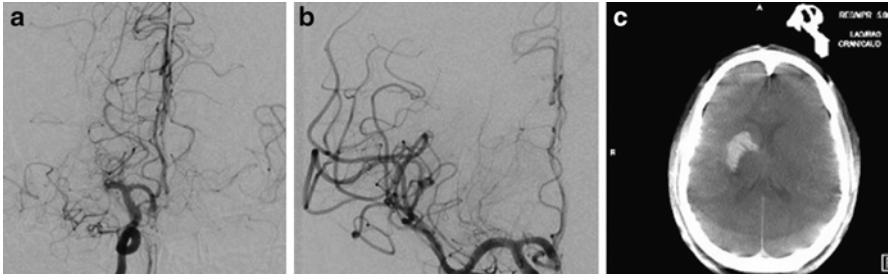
Reperfusion hemorrhage following successful treatment of MCA occlusion. Cerebral angiogram shows a MCA-M1 occlusion (a), which was successfully recanalized (b). Post-thrombectomy computed tomography (CT) shows intracerebral hemorrhage (c)
